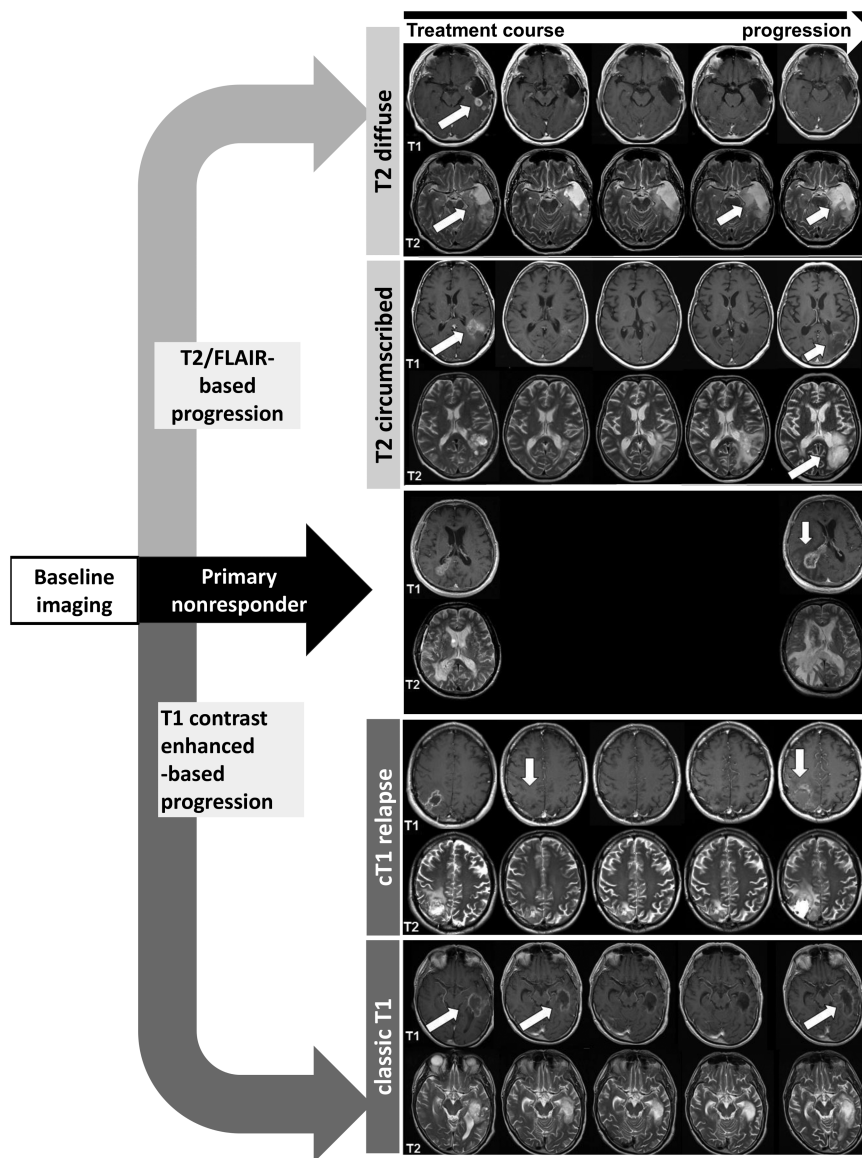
Characterization of progression types. MR images from start of therapy until tumor progression were reviewed for each patient, and categorization of PTs was done according to CE behavior and T2/FLAIR signal changes during therapy. By this approach 5 PTs were characterized: 2 PTs mainly according to T2/FLAIR signal changes (“T2 diffuse” and “T2 circumscribed”), 2 PTs mainly based on CE changes on T1-weighted sequences (“cT1 relapse” and “classic T1”), and some patients showed tumor progression at first follow-up and were classified as “primary nonresponders.” “T2 diffuse”: CE is decreasing in T1-weighted images at first follow-up imaging after treatment initiation. T2 signal is also decreased; only faintly speckled contrast-enhancing lesions are visible at tumor progression. However, these patients show an increase exclusively in T2 hyperintensity, disproportionally larger than the T1 hypointensity, with a homogeneous signal pattern and poorly defined borders on MRI (white arrows). “T2 circumscribed”: A decrease in CE on T1-weighted images is seen at first follow-up imaging after treatment initiation. At progression, a T2-hyperintense tumor progression with an inhomogeneous bulky structure and sharp borders corresponding to a T1-hypointense signal on T1-weighted images can be seen (white arrows). “cT1 relapse”: A complete decrease in CE is visible on T1-weighted sequence during therapy. However, this CE increases again (“relapse”) at tumor progression. T2 signal remains stable or increases. “Classic T1”: An incomplete decrease of CE during therapy at T1-weighted sequences can be seen. At progression, this CE increases. T2 decreases or stays stable initially but increases at progression (white arrows). “Primary nonresponder”: An increase in contrast enhancement is seen at first follow-up imaging after start of therapy. T2 signal stays stable or increases (white arrow).
